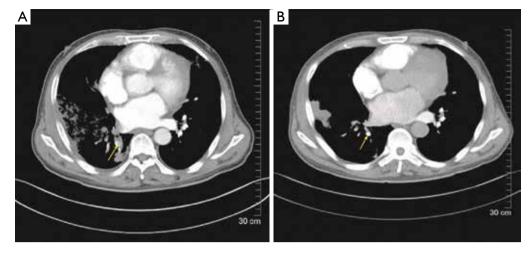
CTA revealed an embolus located in the right inferior pulmonary artery, which was disappeared after the treatment (yellow arrow). CTA, computer tomography angiography.
